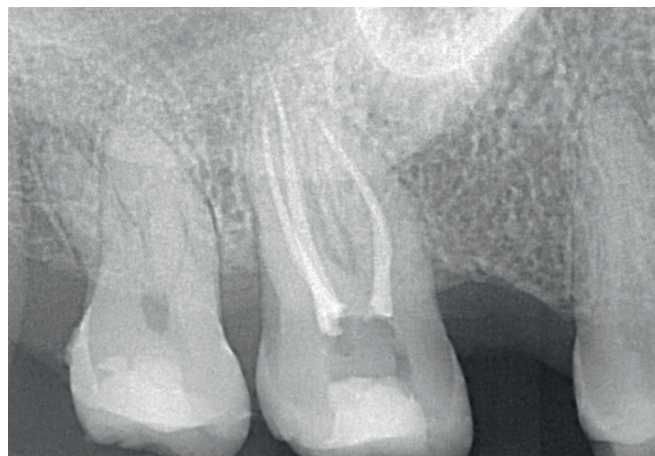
Postoperative radiography showing the shaping and obturation of the three canals.
